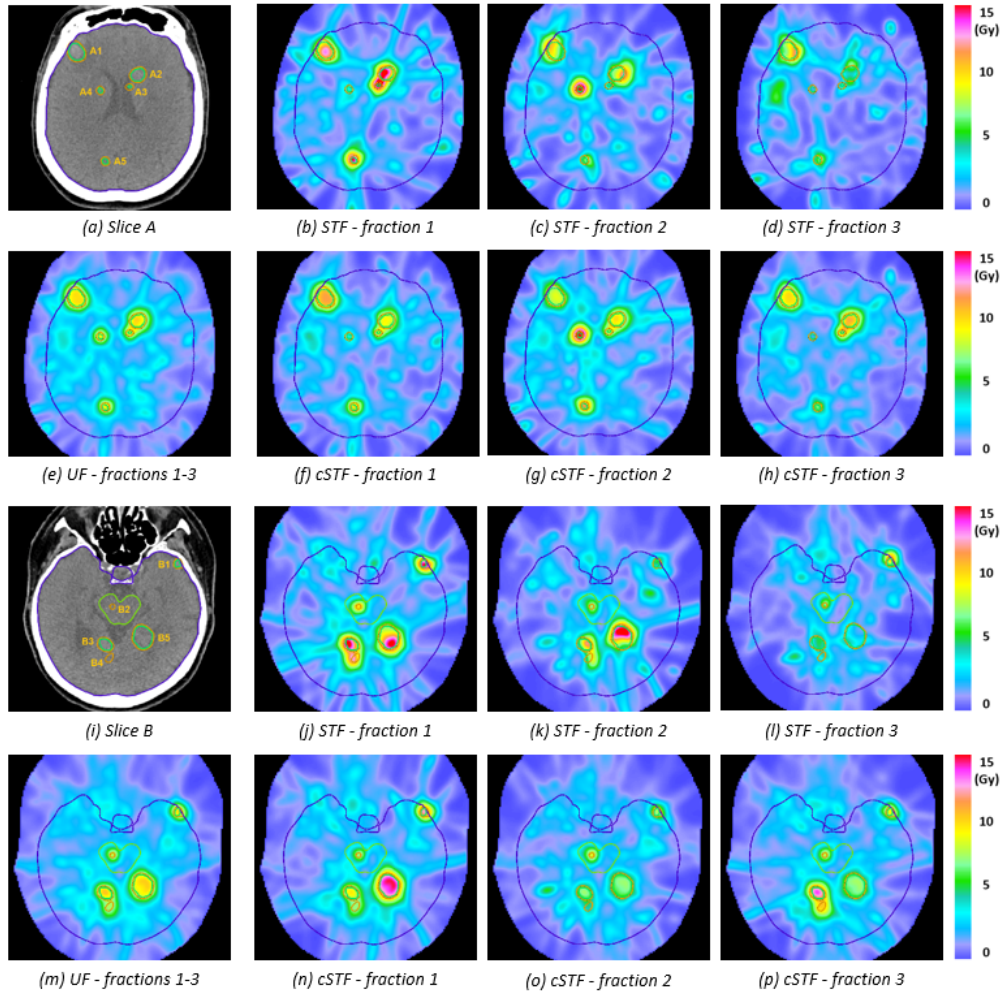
3: Dose distributions for two CT slices of patient 2 achieved with the different fractionation schemes. In slice A (a), five metastases are visible with PTV volumes of 3.5 cc (A1), 3.4 cc (A2), 0.2 cc (A3), 0.2 cc (A4) and 0.4 cc (A5). In slice B (i), five metastases are visible with PTV volumes of 0.3 cc (B1), 0.2 cc (B2), 0.6 cc (B3), 4.7 cc (B4) and 4.2 cc (B5). For each lesion, both contours for the GTV (green) and PTV (orange) are shown. Also shown are the contours of the brain (dark blue) and of the brainstem (light green).
